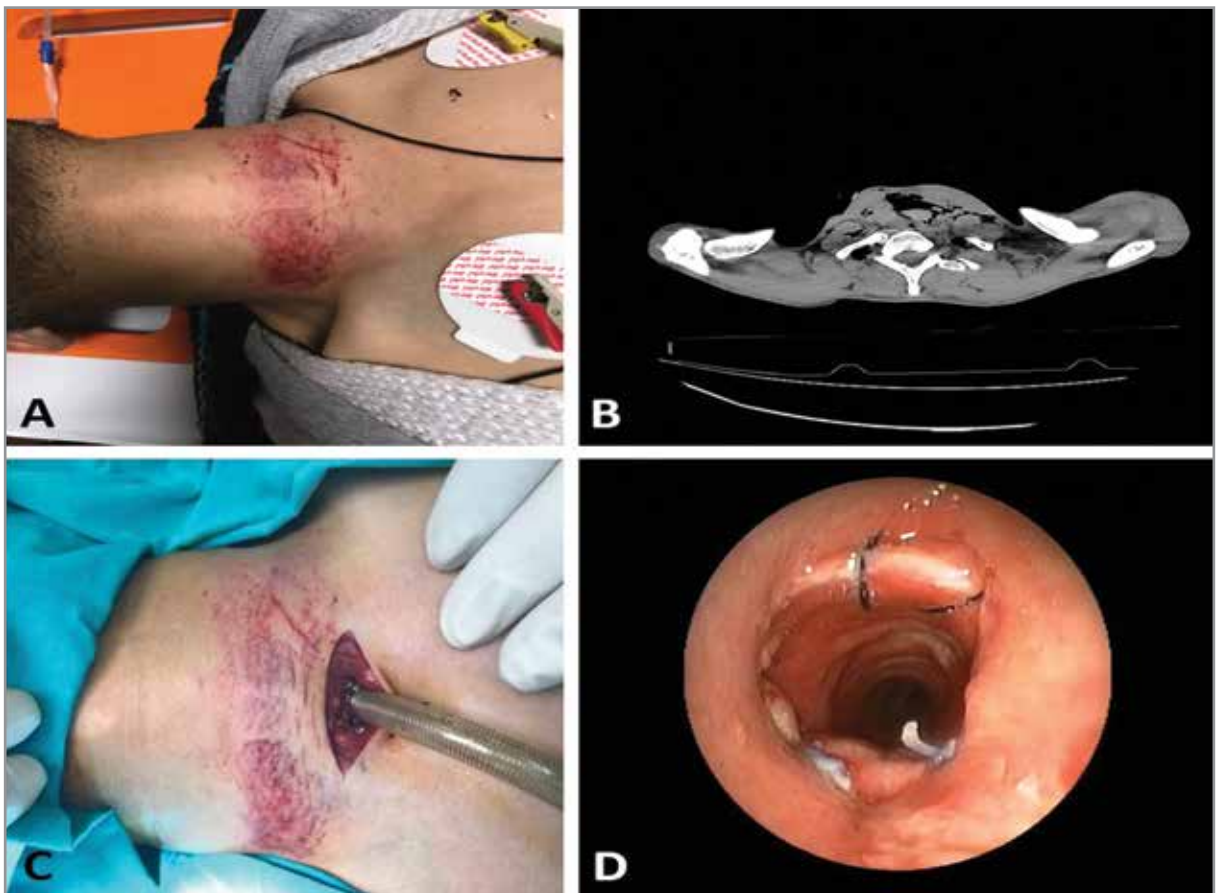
(A) Ecchymosis of the neck region due to blunt trauma, (B) Thorax computed tomography revealed a total rupture of the trachea and subcutaneous emphysema at the level of cervical vertebrae, (C) Tracheostomy was performed and secure airway was obtained, (D) Fiberoptic bronchoscopy of the patient at the 14th day of operation showed an open and patent airway with an anastomosis line around the trachea.
